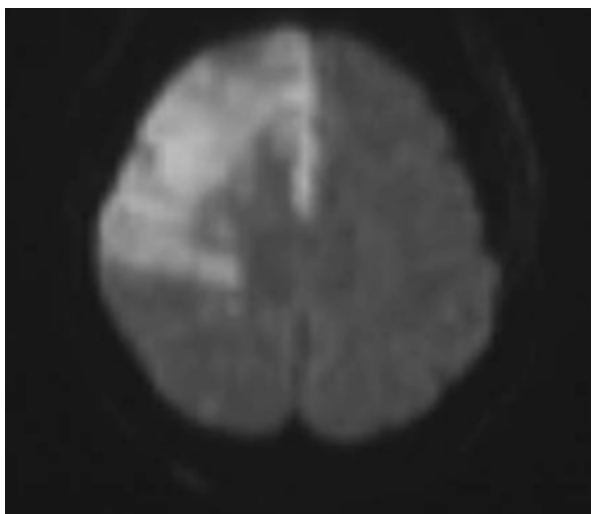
a – Diffusion weighted MRI
